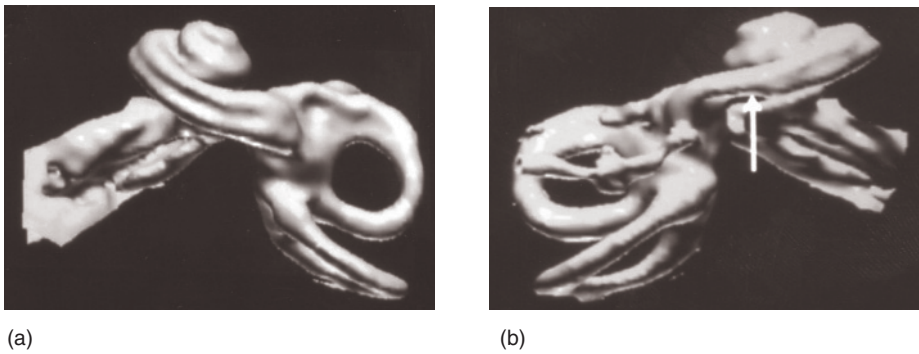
3D MRI images showing (a) normal cochlea and (b) partial loss of the image from the scala tympani as a result of obliteration.
